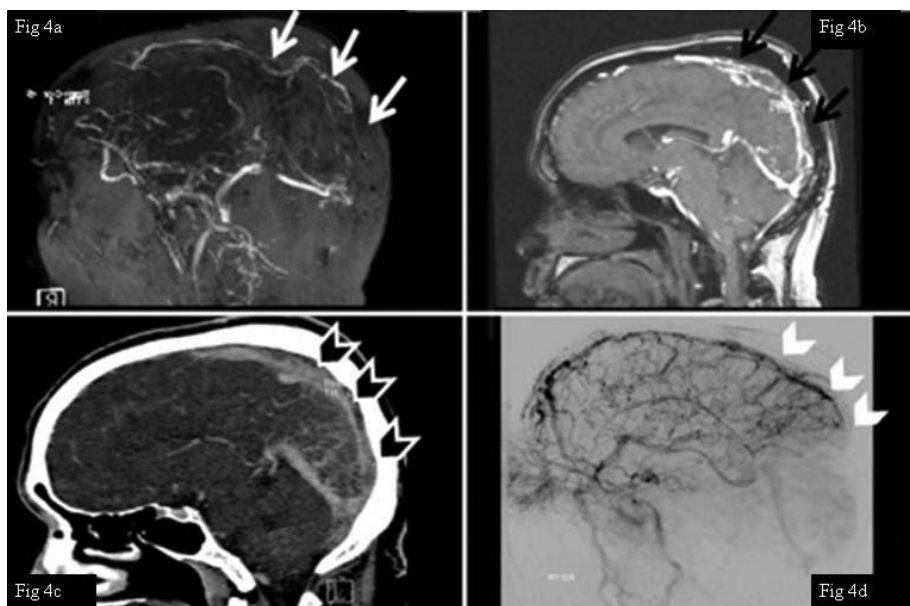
2D-TOF MRV lateral projections showing poorly opacified superior sagittal sinus (SSS) (white arrows). Contrast enhanced sagittal T1-weighted MR image (black arrows) (4b); Sagittal reformatted CTV image (4c) demonstrated filling defects along the SSS (black arrowheads). Figure 4d. Venous phase of the cerebral angiogram shown in lateral view confirmed filling defects within the posterior ½ of SSS in keeping with thrombosis (white arrowheads).
